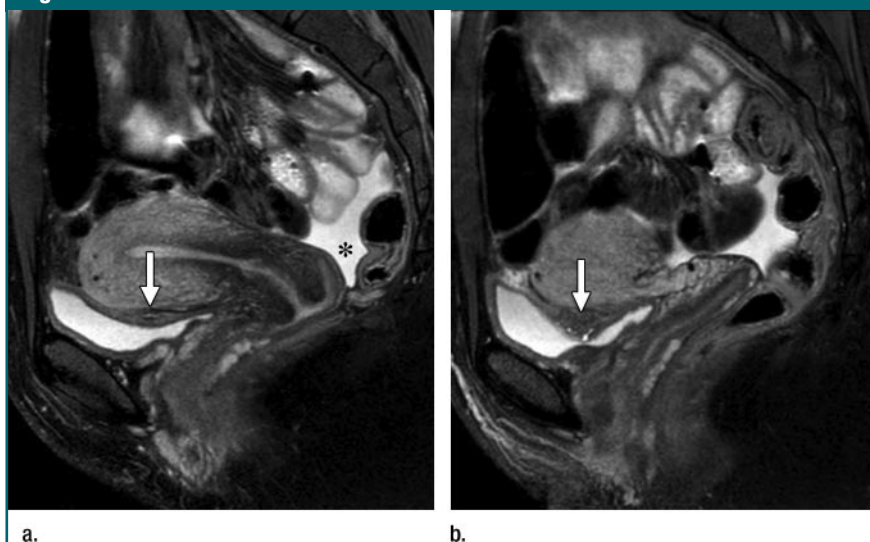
(a, b) Sagittal fat-suppressed TSE T2-weighted MR images (3835/48) in 37-year-old woman show (a) normal appearance of the uterus, Douglas pouch (*), and vesicouterine pouch (arrow) and (b) deep endometriosis of the vesicouterine pouch infiltrating the bladder wall (arrow).
